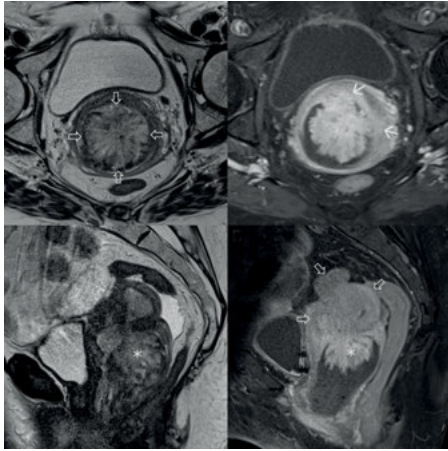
MRI of the patient from Fig. 7.1.2 (E), (F); as described, the tumor prolapsed from the vulva causing uterine inversion two days after this MRI was taken; axial and sagittal T2 weighted images (upper and lower left) show a tumor that is heterogeneously hyperintense to the smooth musculature. Upon i.v. administration of contrast agent and fat suppression, the axial and sagittal T1 weighted images (upper and lower right) reveal a tumor with a diameter of no more than 5 cm. The tumor presents with an actiniform growth pattern in all images (large arrows) and protrudes from the uterus into in vagina (stars). The tumor causes the vagina to expand. In addition, the left side of the vagina has been infiltrated by the tumor (thin arrows). Urinary bladder and rectum are not involved.
